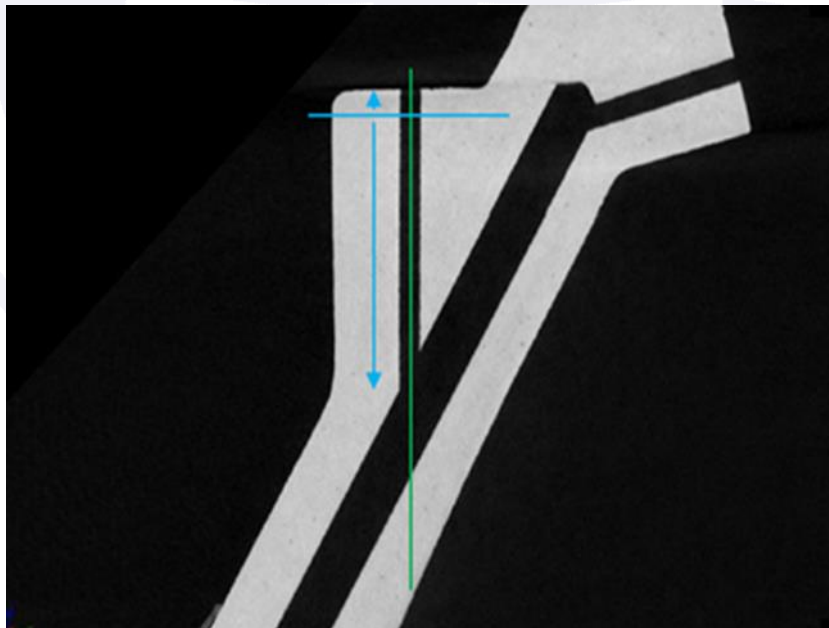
Radiograph of the *piccolo tube*.
